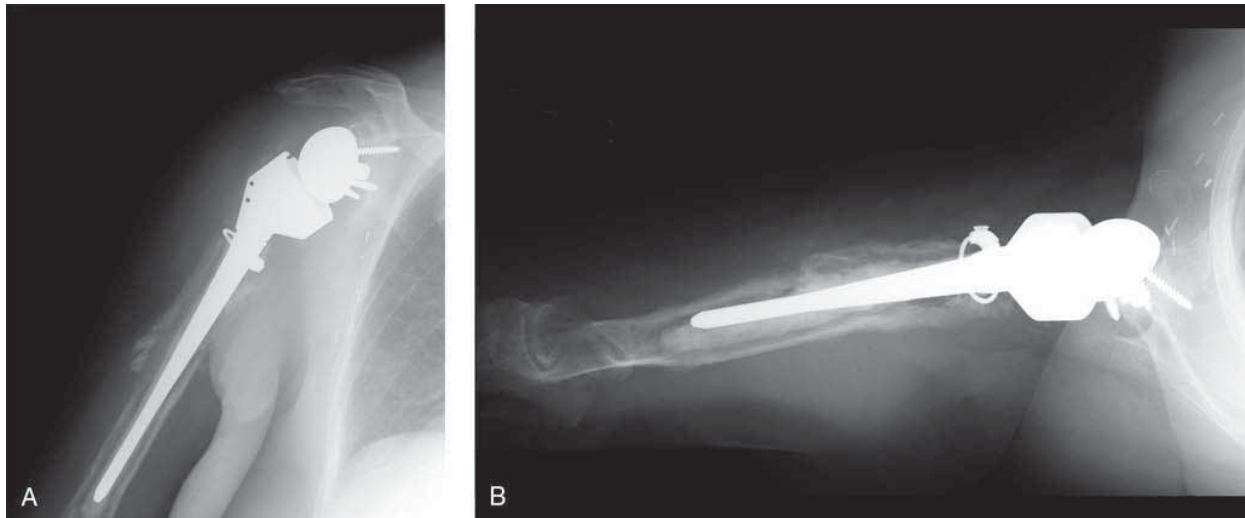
AP (A) and axillary (B) radiographs of the shoulder of a 60-year-old woman with an infected long-stem reverse prosthesis. Significant periprosthetic lucency and periosteal new bone formation are present.
